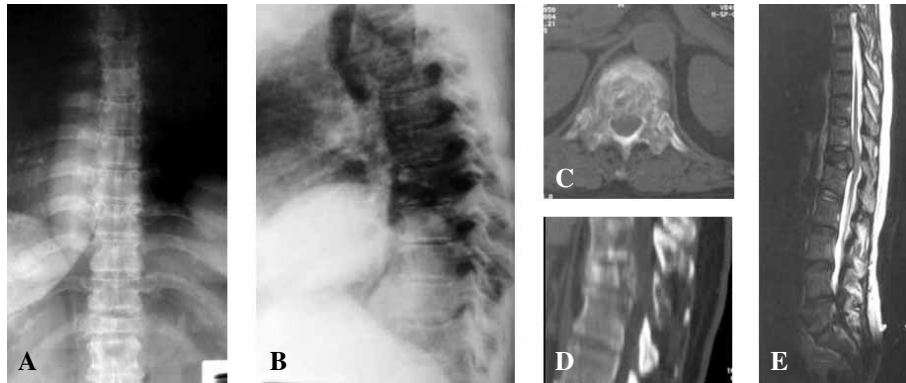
A 67-year-woman with T12 metastatic lung cancer of small cell carcinoma type. She had no neurological deficit and she underwent radiotherapy rather than surgery. (A) Anteroposterior and (B) lateral plain radiographs show the compression of the T12 vertebra. Axial (C) and sagittally reconstructed (D) CT scans show vertebral destruction with minimal spinal canal compression, and sagittal MRI (E) shows the lesion.
